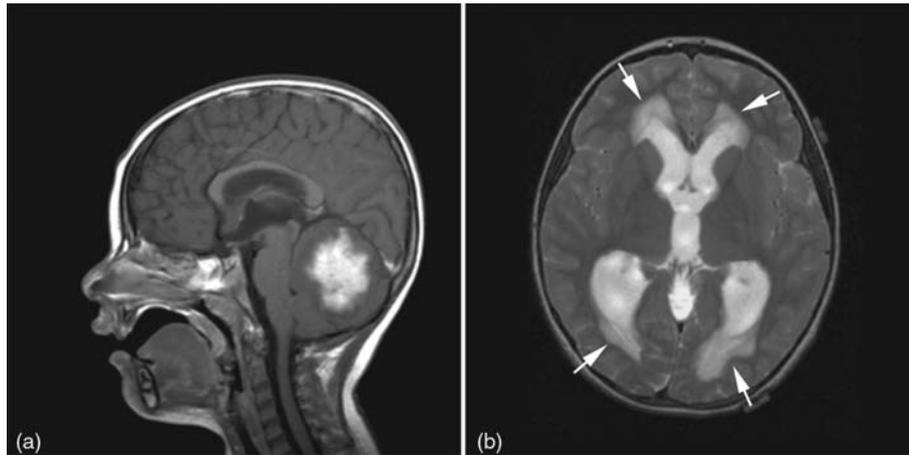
(a) Sagittal gadolinium-enhanced magnetic resonance (MR) image of a cerebellar pilocytic astrocytoma in a child. Note that the tumor is comprised of a large enhancing nodule as well as a surrounding cyst. (b) Axial T2-weighted MR image demonstrating obstructive hydrocephalus in the lateral and third ventricles with transependymal resorption of cerebrospinal fluid (arrows) resulting from compression of the cerebral aqueduct by the large cerebellar tumor.
